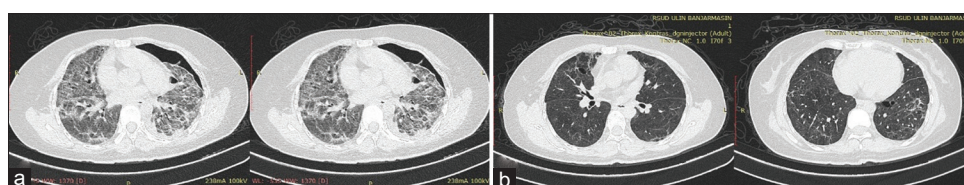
Chest CT-scan findings. (a). Chest CT scan on day 27 of hospitalization (13 days after discharge from isolation room; 37 days from onset) showed pulmonary fibrosis and ground-glass opacities complicated by left pneumothorax. (b). Chest CT scans 36 days after discharge (63 days from onset) showed complete lung expansion bilateral, with fibrosis and bullous emphysema subpleural bilateral
